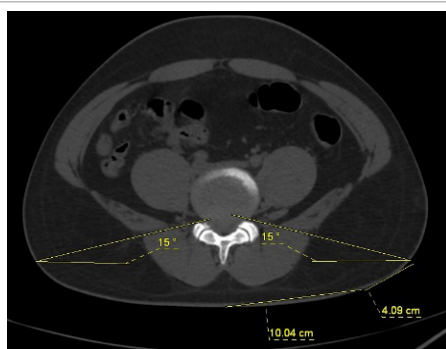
Pre op CT scan - optimum position for guide pin insertion found out using pre op axial CT scan and found to be upto but < 14 cm from midline.
